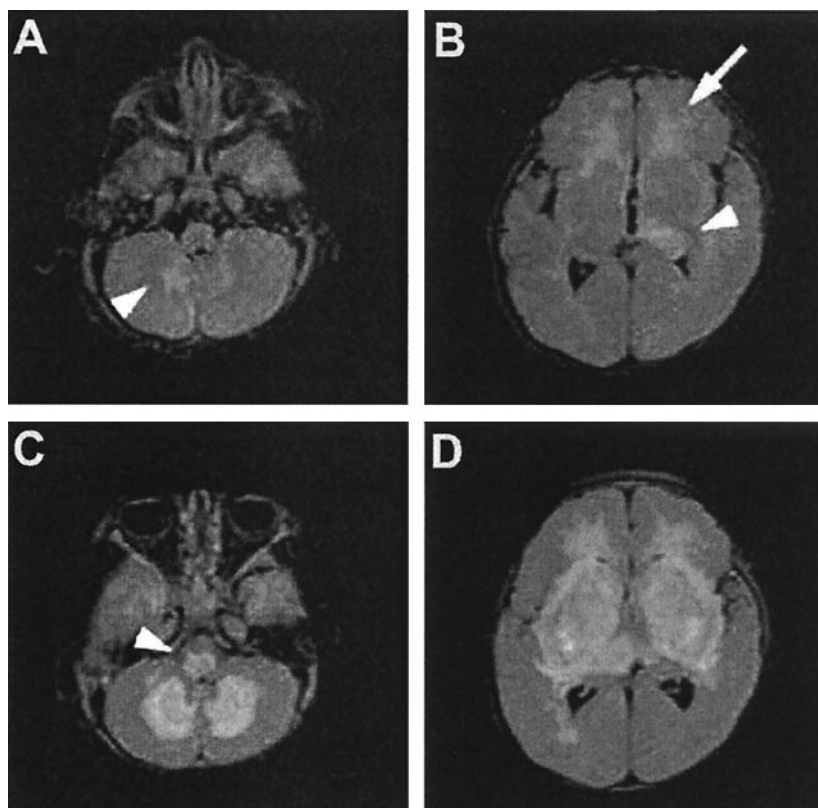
MRI imaging from patient 8. A and B, Axial FLAIR MRI from first admission showing altered signal in deep cerebellar nuclei (A, arrowhead), in frontal white matter (B, arrow), and in thalami (B, arrowhead). C and D, Axial FLAIR MRI from second admission is consistent with a necrotizing encephalitis. Arrowhead in C points to new lesion in the pons.
